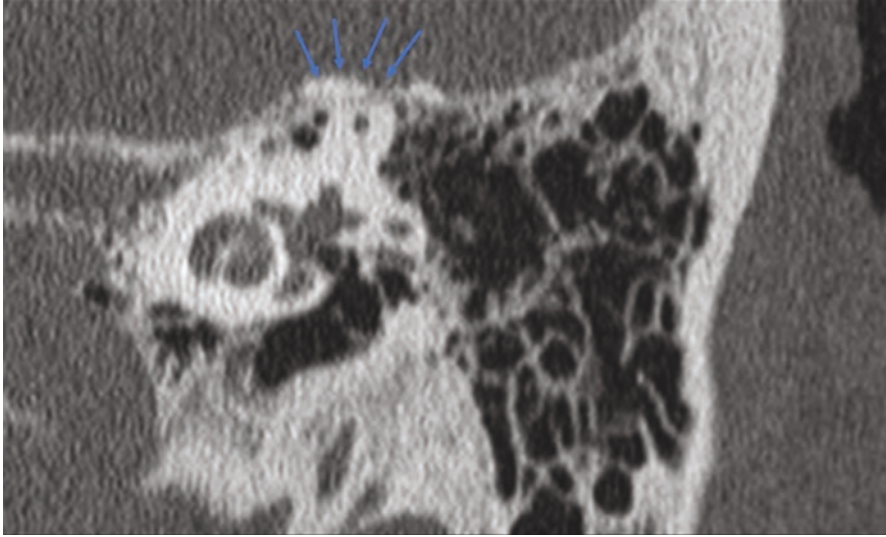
Preoperative CT scan of a patient who underwent resurfacing with HA cement but had persistent symptoms. The CT demonstrates what appears to be a well repaired SSCD. VEMP and ECOG testing were unremarkable and suggested successful surgical repair. However, fistula testing demonstrated vertical/torsional phase-locked eye movements in the plane of superior canal, strongly implicating a persistent SSCD despite the CT scan. Valsalva testing was also abnormal. Surgical exploration revealed HA cement that had failed to cure and was non-rigid, thus allowing continued pressure transmission. Revision surgical repair with calvarial bone resolved his symptoms. Arrows point to the “uncured” HA cement
